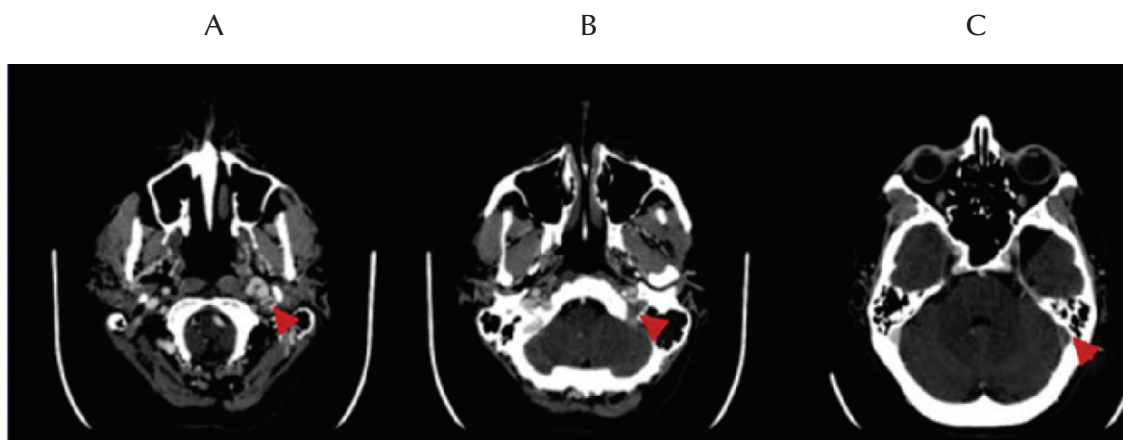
Initial computed tomography scan of the brain with contrast enlargement. Thrombosis is noted in the left sigmoid and transverse sinuses with filling defect in the left internal jugular venous system. Arrows delineate the findings. The image on the left (A) contains a hyperdense signal at the tip of the arrow, consistent with a subacute-to-acute thrombus. Filling defects are demonstrated in the following venous structures: (A) involves the left internal jugular vein, (B) corresponds to the sigmoid sinus, and (C) involves the sigmoid–transverse sinus junction.
